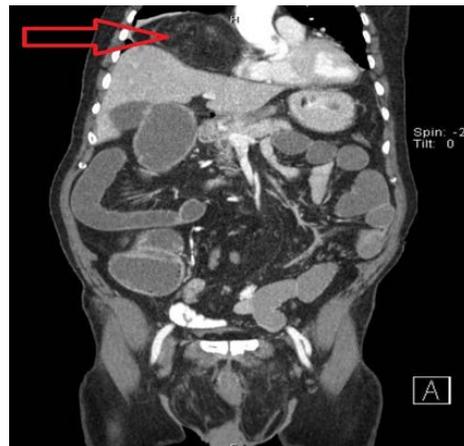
Computed tomography; omentum in hernia sac is demonstrated with red arrow
